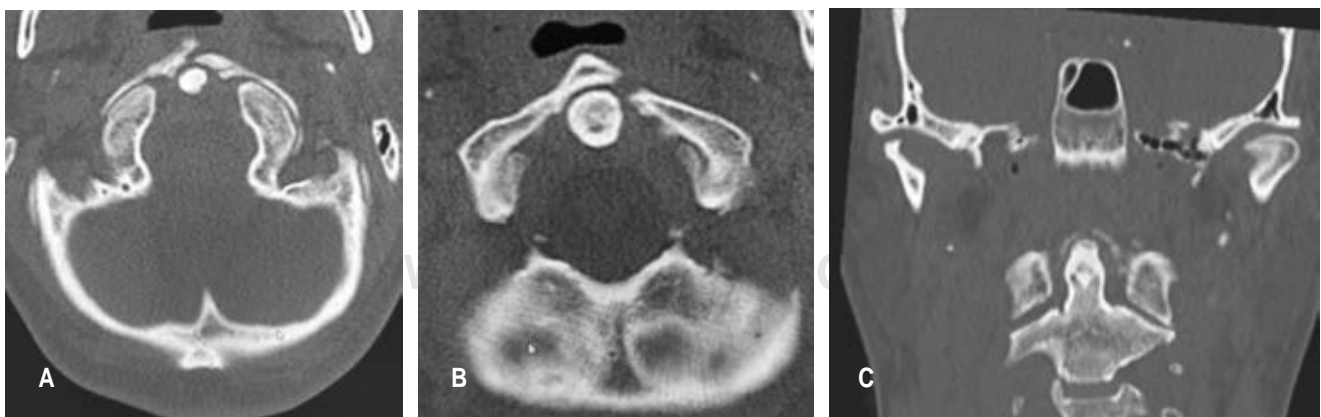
Simple CT scan. A) Axial view showing integrity of the occipital condyles and anterior arch fracture of C1. B) Axial view anterior arch fracture of C1. C) Coronal view integrity articulation C1-C2.
